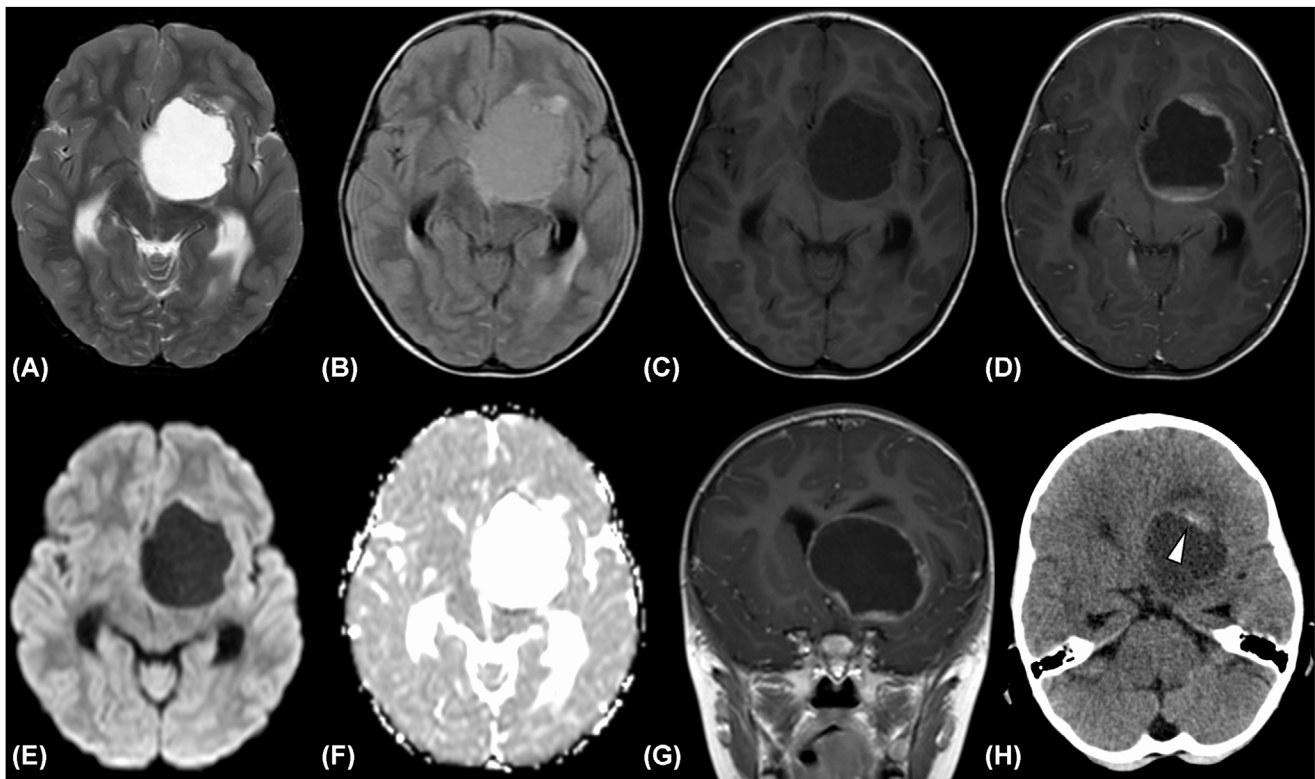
Supratentorial low-grade astroblastoma in a 3-year-old girl presenting with headache (patient 2). The solid components of the tumor show iso and low intensity on T2-weighted image (A), high intensity on fluid-attenuated inversion recovery image (B), and low intensity on T1-weighted image (C) with heterogeneous enhancement (D). Diffusion restriction is observed with the mean apparent diffusion coefficient value of $0.65 \times 10^{-3} \text{mm}^2/\text{s}$ (E, F). The tumor shows a cystic mass with irregular rim (morphology III) and ependymal contact on postcontrast coronal T1-weighted image (G). Unenhanced CT shows partial calcification (H, arrowhead)
